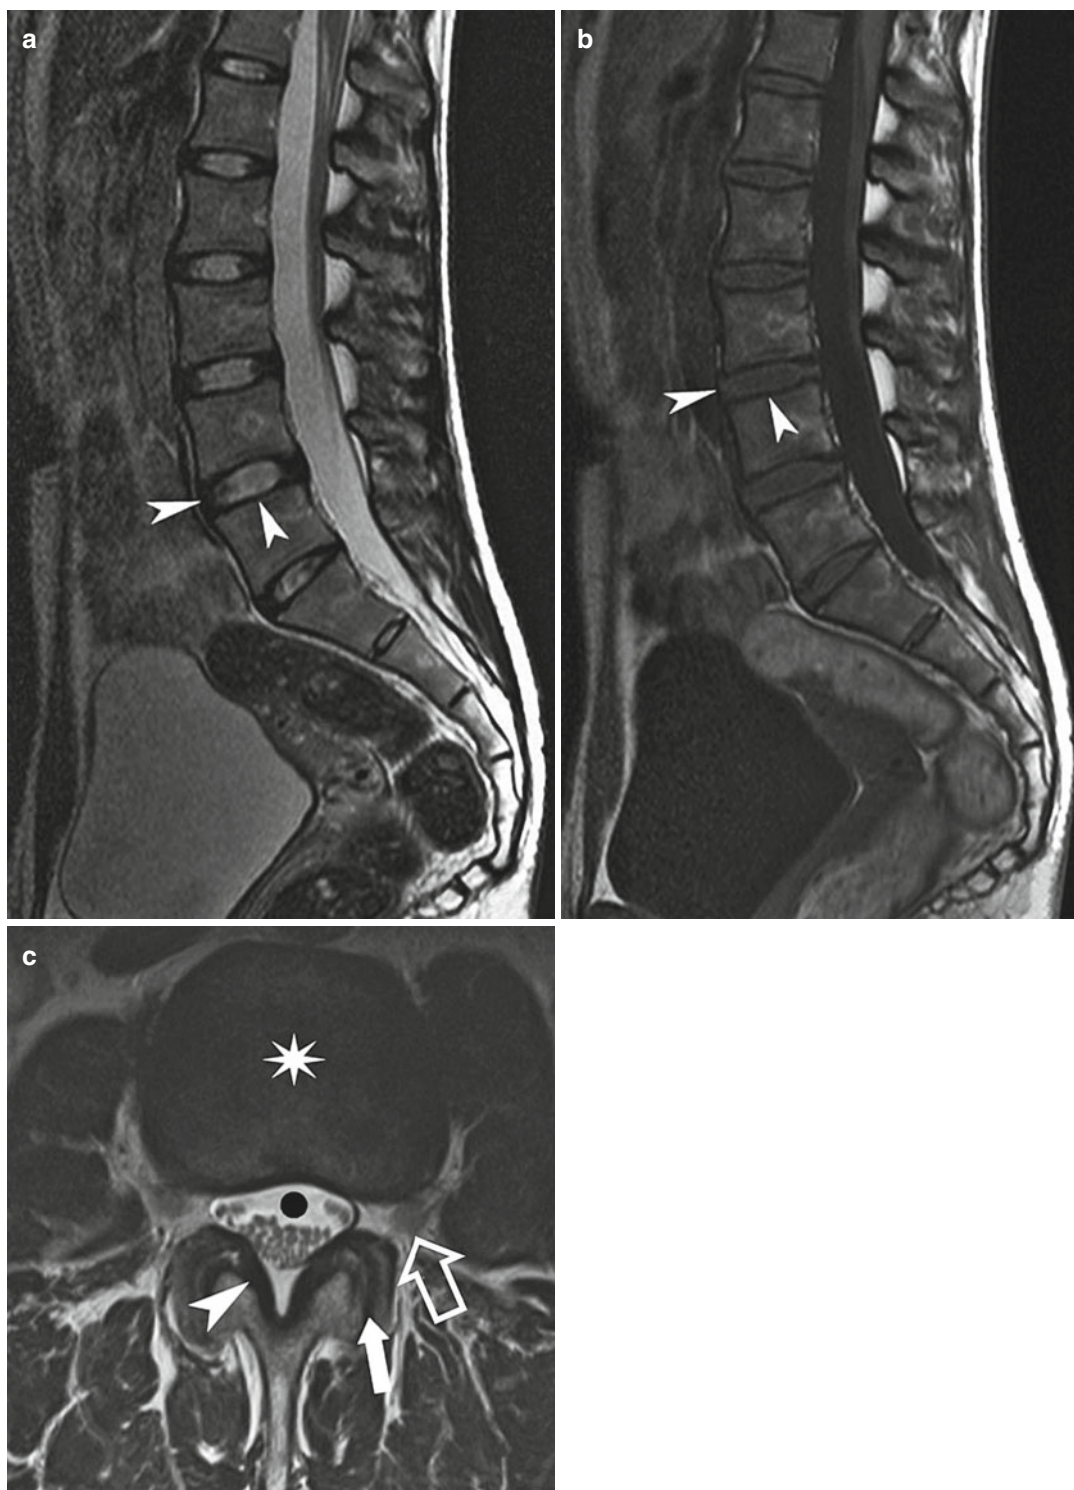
Lumbar spine, MRI sagittal imaging, TSE T2-weighted (a) and T1-weighted (b) and axial T2-weighted images (c). On T2WI, the intervertebral discs are hyperintense and hypointense on T1WI in connection with their fluid content. The annulus fibrosus
